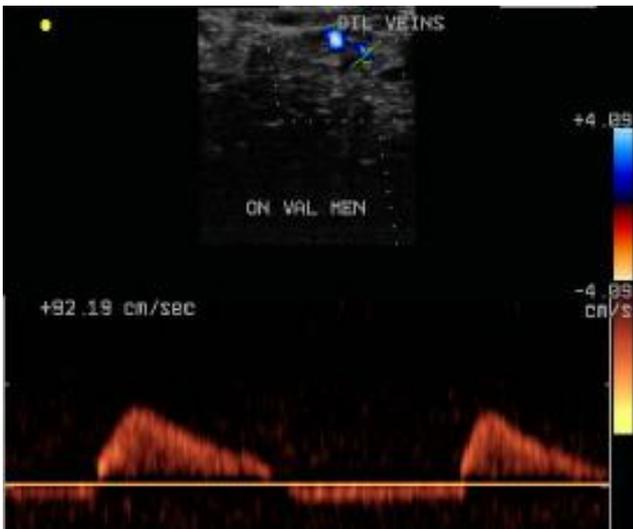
d: Flow reversal on power Doppler (Flow reversal on power Doppler)
